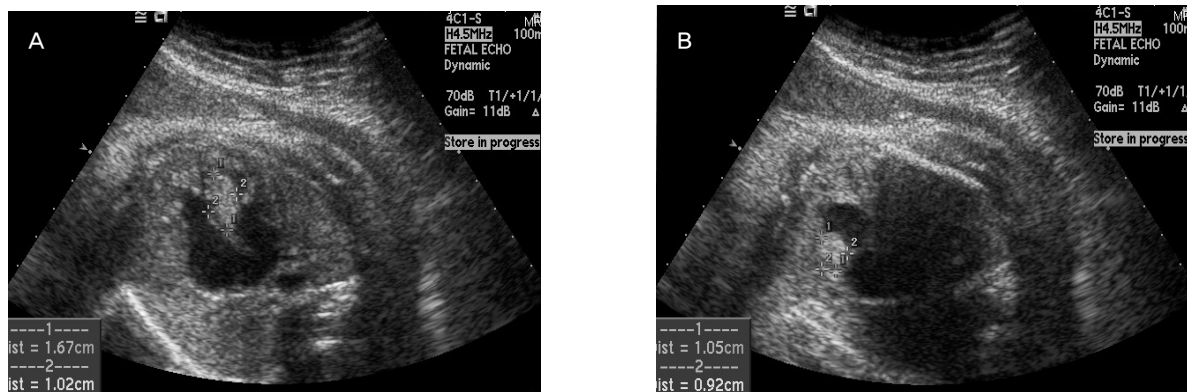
The prenatal sonographic findings of fetal rhabdomyomas of case No.10 (A) largest mass on the interventricular septum, (B) another mass on the posterior wall of LV.
